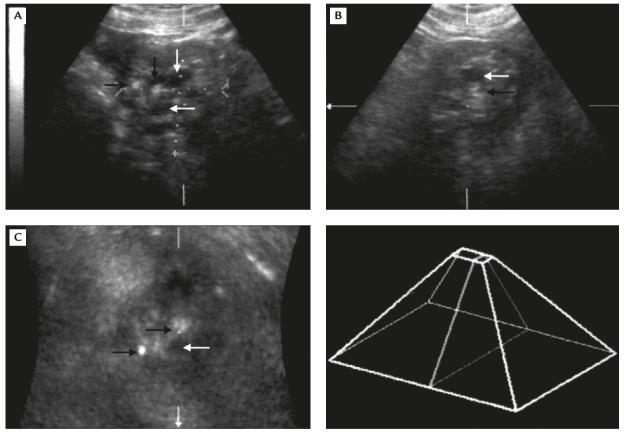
Three-dimensional orthogonal sonography of the growing teratoma syndrome tumors, obtained after completion of six cycles of the cisplatin, etoposide and bleomycin chemotherapy with normal α -fetoprotein. Three (A) X, (B) Y, and (C) Z axial images disclosed punctate calcifications (black arrows), scattered anechoic holes (white arrows), and smooth margins in all three axis.
